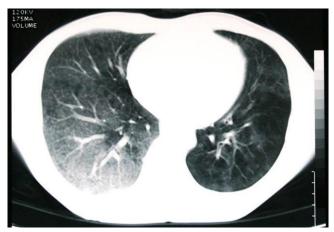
Ground-glass densities in the right lower lobe and air trapping in the left lung in the thoracic CT before treatment
